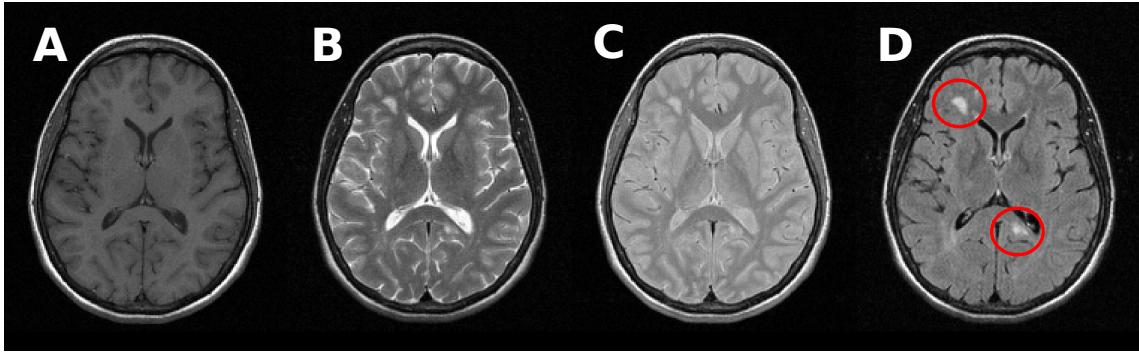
MRI image modalities. A) T1-weighted (T1-w) image sequence. B) T2-weighted (T2-w) image sequence. C) Proton Density-weighted (PD-w) image sequence. D) Fluid Attenuated Inversion Recovery (FLAIR) sequence. MS plaques are shown inside red circles on the FLAIR modality. MS plaques are hypointense with respect to GM and WM in T2-w, PD-w and FLAIR sequences, while hypointense with respect to WM on the T1-w modality.
